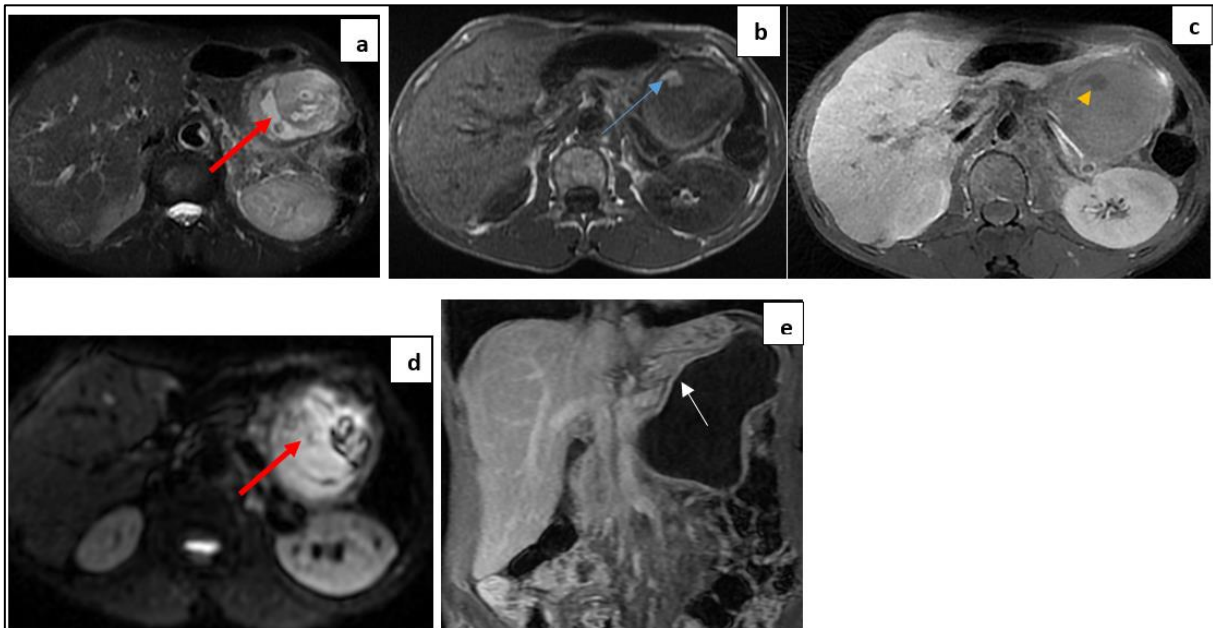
Abdominal MRI in axial and coronal sections with weighted sequences: T1 (b), T2(a), T1 Fatsat (c), diffusion (d) and T1 after injection of gadolinium (e) :
